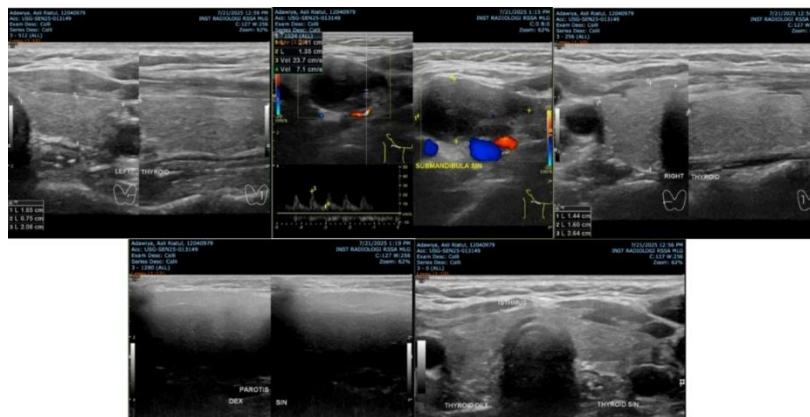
Cervical ultrasonography showing multiple malignant-appearing lymphadenopathies in the bilateral submandibular, right perijugular, and submental regions.
